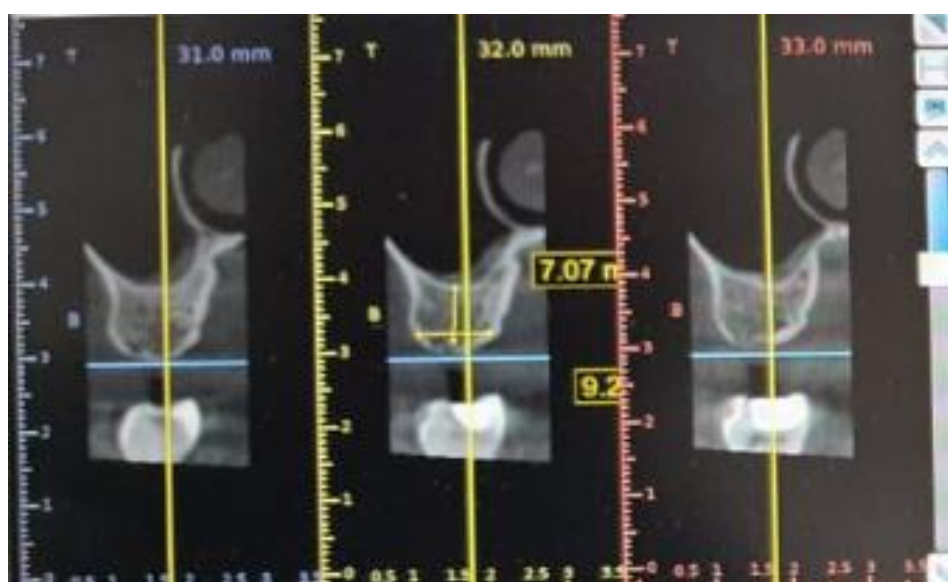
Pre-operative CBCT
